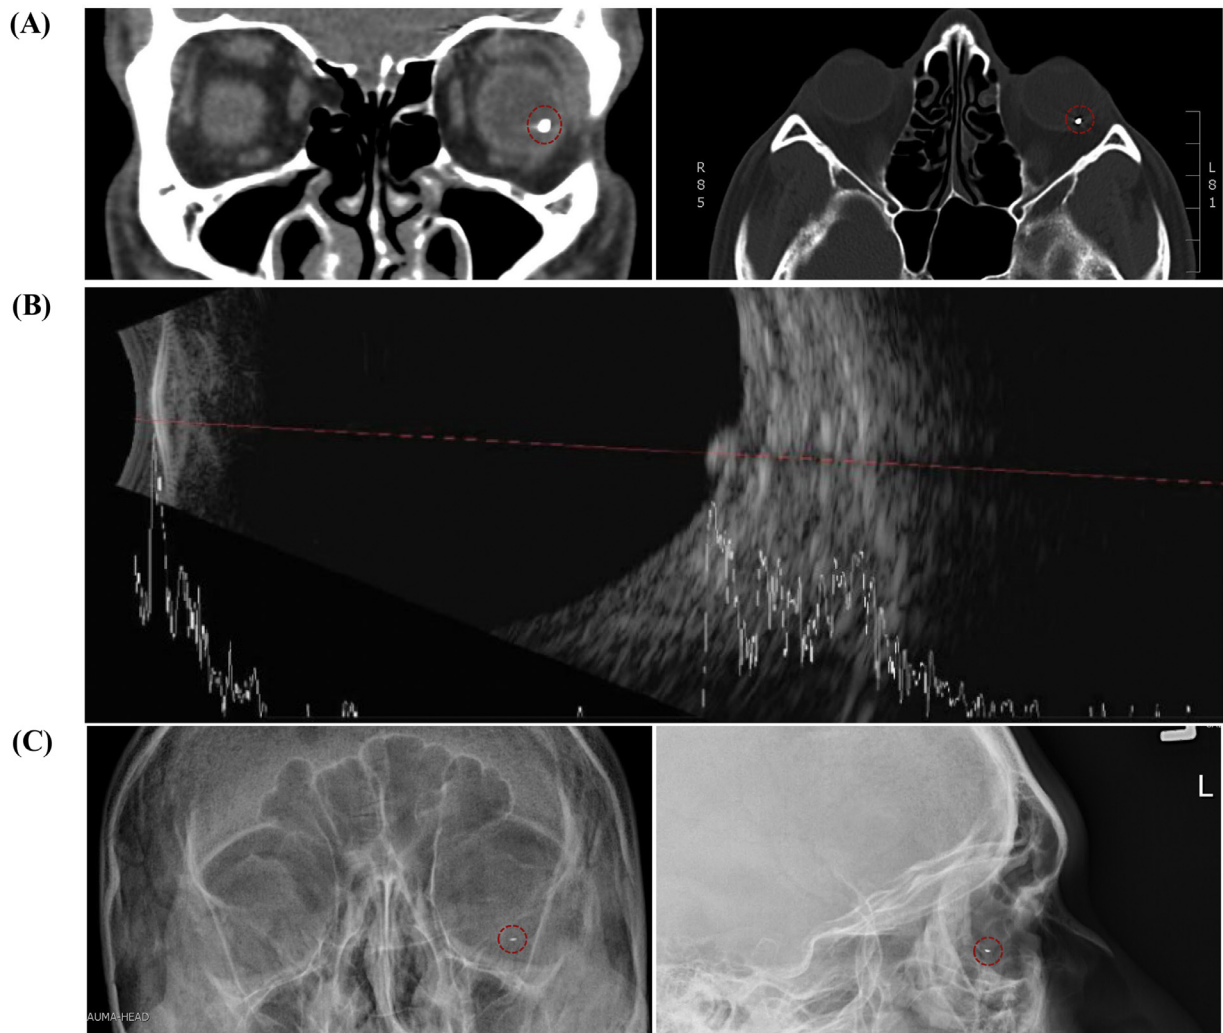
Diagnostic imaging of IOFB. (A) CT of a 3-cm IOFB in the temporal macula of the retina. (B) B-scan of a 1.5-mm IOFB in the inferotemporal retina. (C) X-ray of 3-mm IOFB in the temporal macula. IOFB, intraocular foreign body; CT, computed tomography; B-scan is bright-scan ultrasonography.
